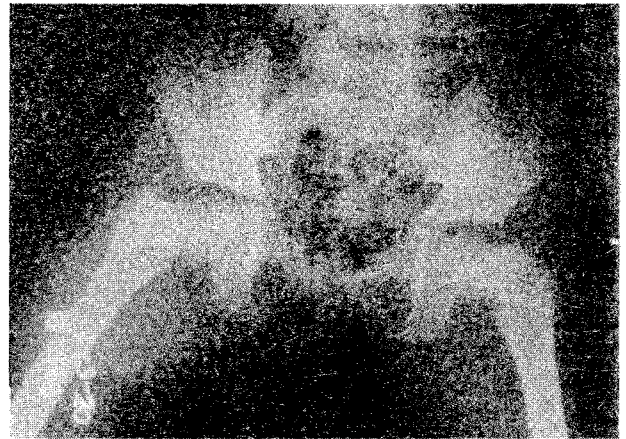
X-ray of the pelvis of the five and a half year old girl with bilateral cervico-trochanteric fracture of the neck of the femur.
